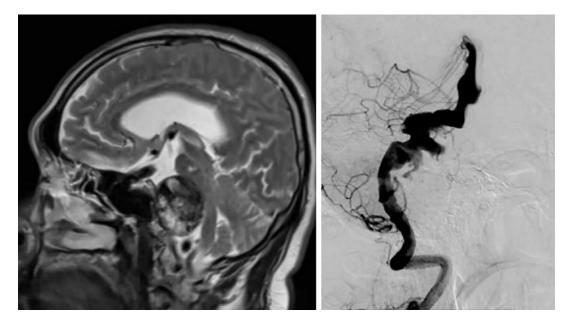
A patient presented with symptoms of mass effect from vertebrobasilar transitional aneurysm. MRI revealed the partially thrombosed and superimposed dilation portion of basilar artery with compression of brain stem
